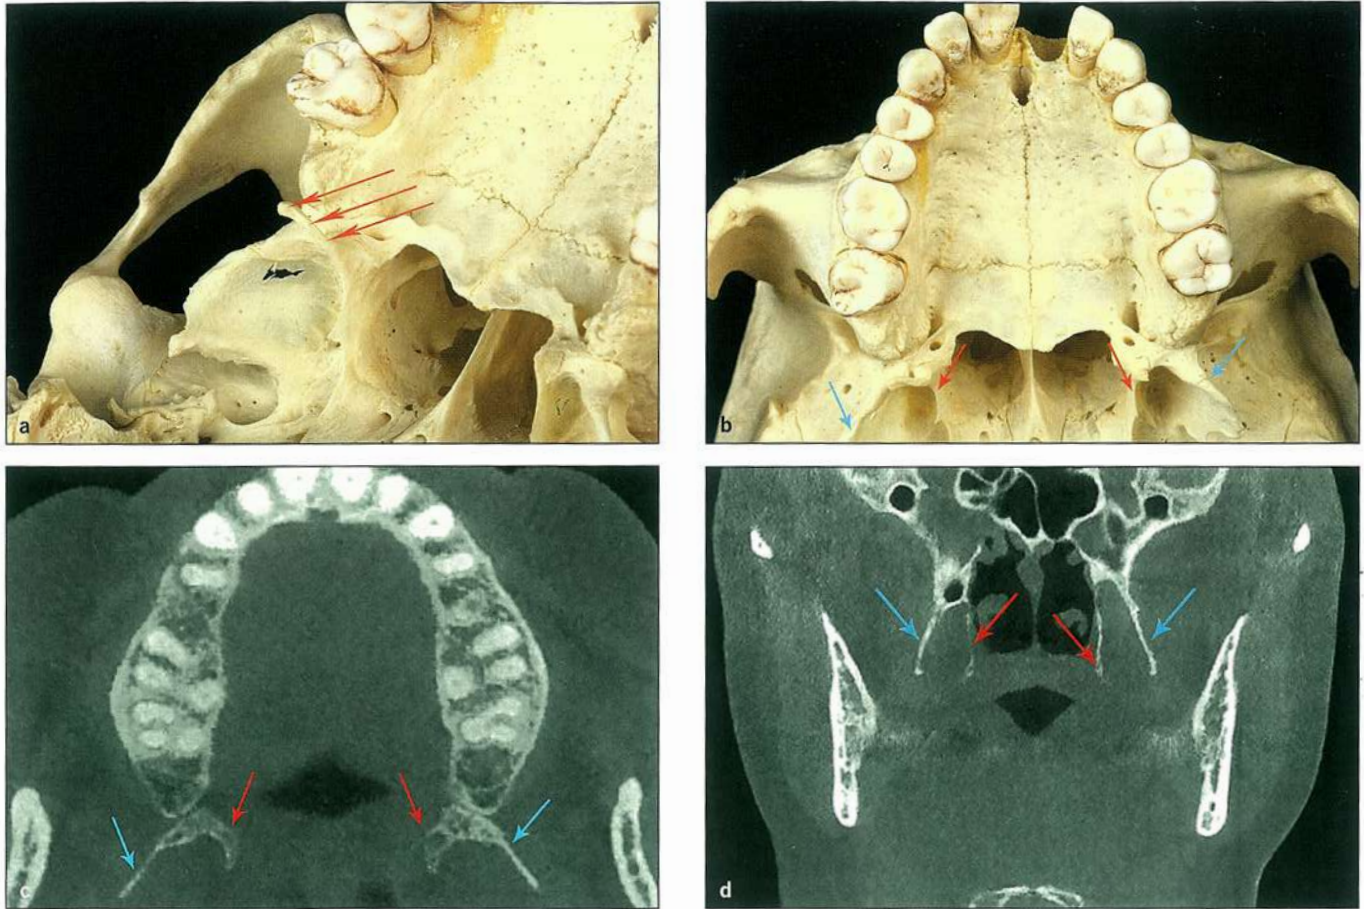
(a) At the inferior tip of the medial pterygoid plate, just posterior to the lateral aspect of the hard palate, is a hooklike process called the *hamulus* (red arrows). (b and c) The medial (red arrows) and lateral (blue arrows) pterygoid plates of the sphenoid bone seen in axial view in dry skull and CBCT images. (d) Coronal CBCT image showing the medial (red arrows) and lateral (blue arrows) pterygoid plates.
